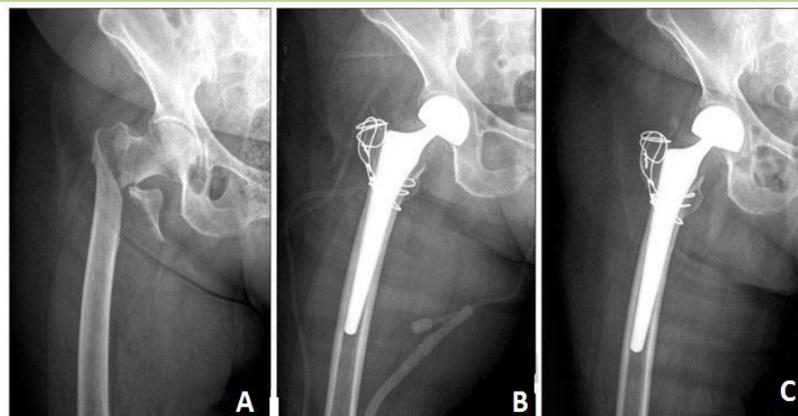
(A) a 70-year-old female patient had an unstable intertrochanteric fracture. (B) The postoperative radiograph shows a good proximal canal fit and wiring. (C) At postoperative 12 months, the radiograph shows stable fixation of the femoral stem.
